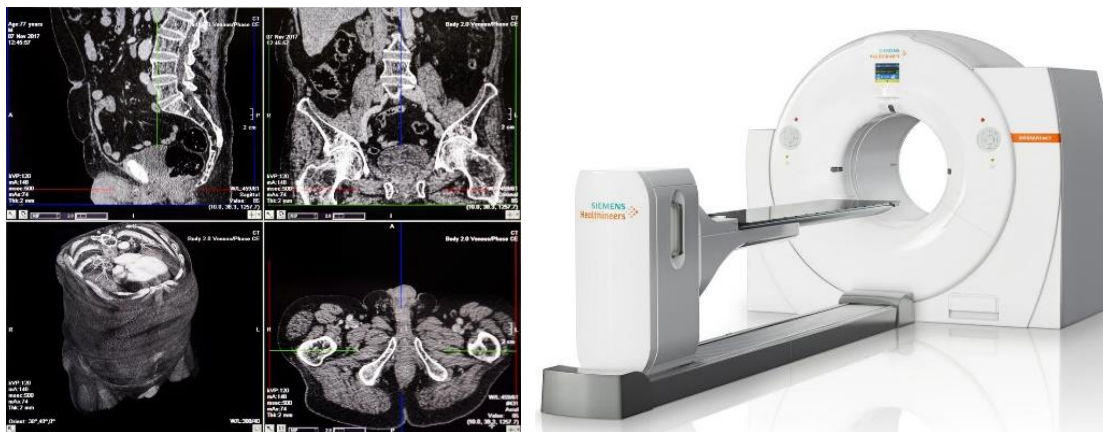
Left: Examples of anatomical CT images showing different slices (www.medicalnewstoday.com). Right: Photograph of a commercial CT scanner (www.siemens-healthineers.com).
